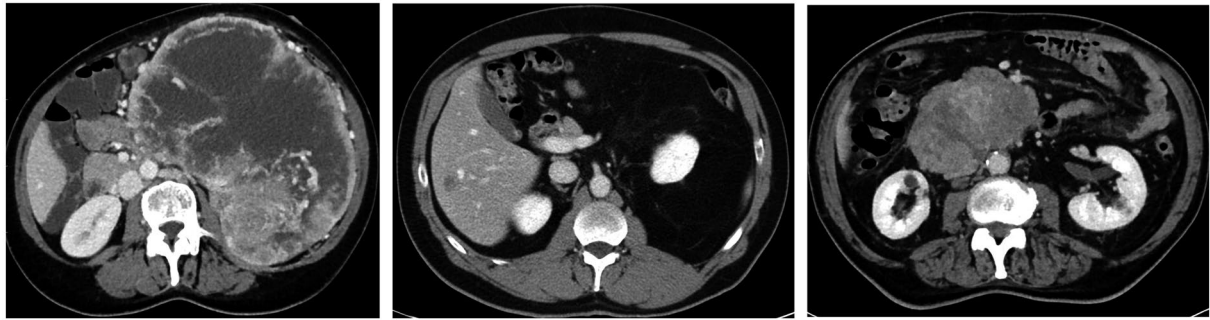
Preoperative Computed Tomography Imaging of Soft-Tissue Sarcoma Aids in Establishing a Diagnosis and in Determining the Local Extent of a Lesion and its Relationship to Adjacent Structures. Images show (Left) dedifferentiated liposarcoma, (Middle) well-differentiated liposarcoma, and (Right) leiomyosarcoma.
